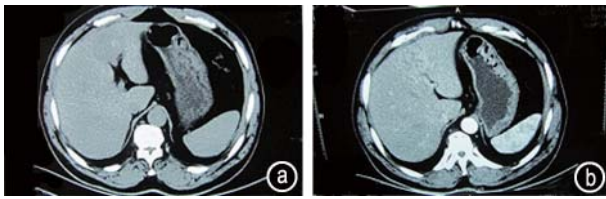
(a) Computed tomography (CT) scan showing a 3.7 cm × 3.4 cm mass in the left lobe of the liver that appeared round in shape and uneven in density. (b) Contrast-enhanced CT scan displaying a 3.7 cm × 3.5 cm well-defined hepatic mass in the left internal lobe of the liver, which showed low-density enhancement
